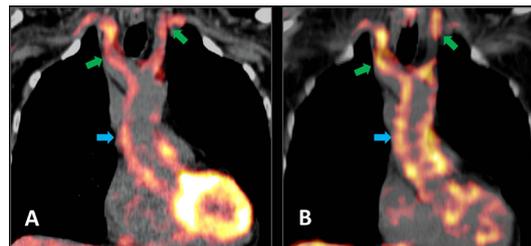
(A) (18)F-fluorodeoxyglucose positron emission tomography-CT (PET-CT) presented inflammatory activity of the aortic wall (blue arrow) and supraaortal arteries (green arrows) indicating a giant cell arteritis resulting in the initiation of an tocilizumab therapy and (B) the (18)F-fluorodeoxyglucose uptake of the aorta and supraaortal arteries in PET-CT in association with anew pain, stiffness in the shoulder girdle and occipital headache under the therapy with tocilizumab revealed a flare of giant cell arteritis.
